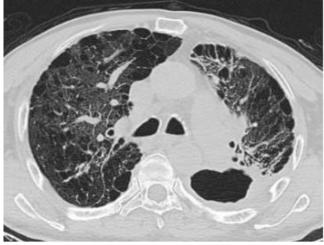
Emergency room CT revealing the cavitary consolidation in the left lower lobe
